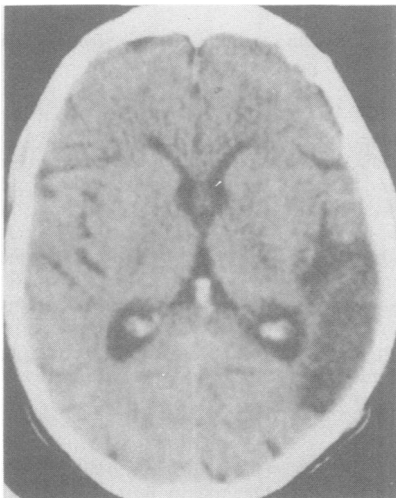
Fig CT scan showing infarction in the right temporo-parietal area.
